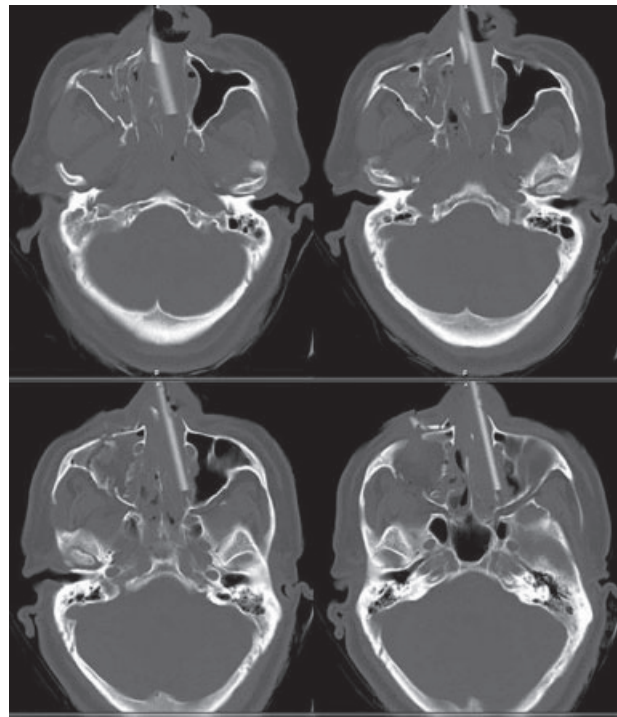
CT scan of the face region (bone window) showing the broken pipe and associated facial bone fractures.
